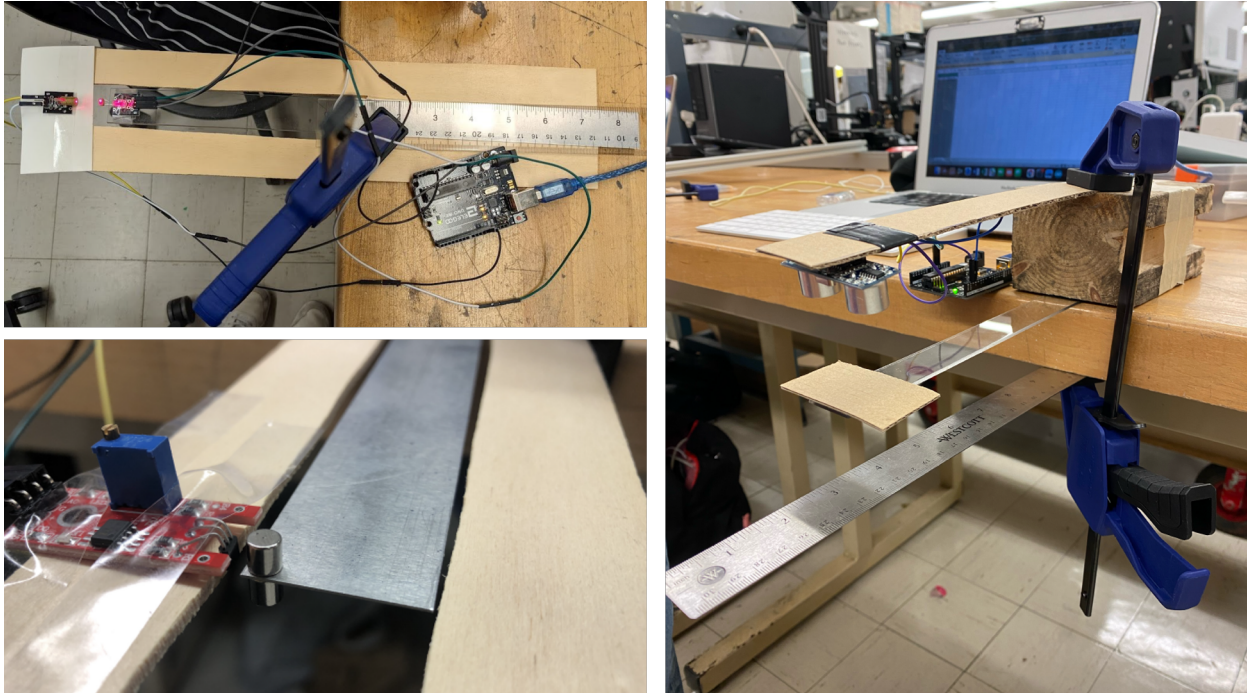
Three examples of student apparatuses for measuring the free vibration of acrylic and aluminum beams. The top-left image shows a photo resistor and a laser emitter setup. Bottom-left shows a magnet with a hall effect sensor. Right shows an ultrasonic sensor.
